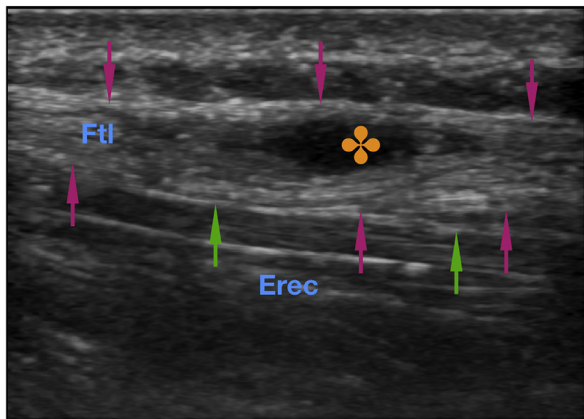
A 15 MHz sonogram of a lipoma (golden asterisk) located between the posterior layer of the thoracolumbar fascia (Ftl, magenta arrows) and the fascia of the erector spinae (Erec, green arrows) in a 13-y-old girl. Only during movement does the girl suffer from pain caused by movement of the lipoma between both fascia layers.
